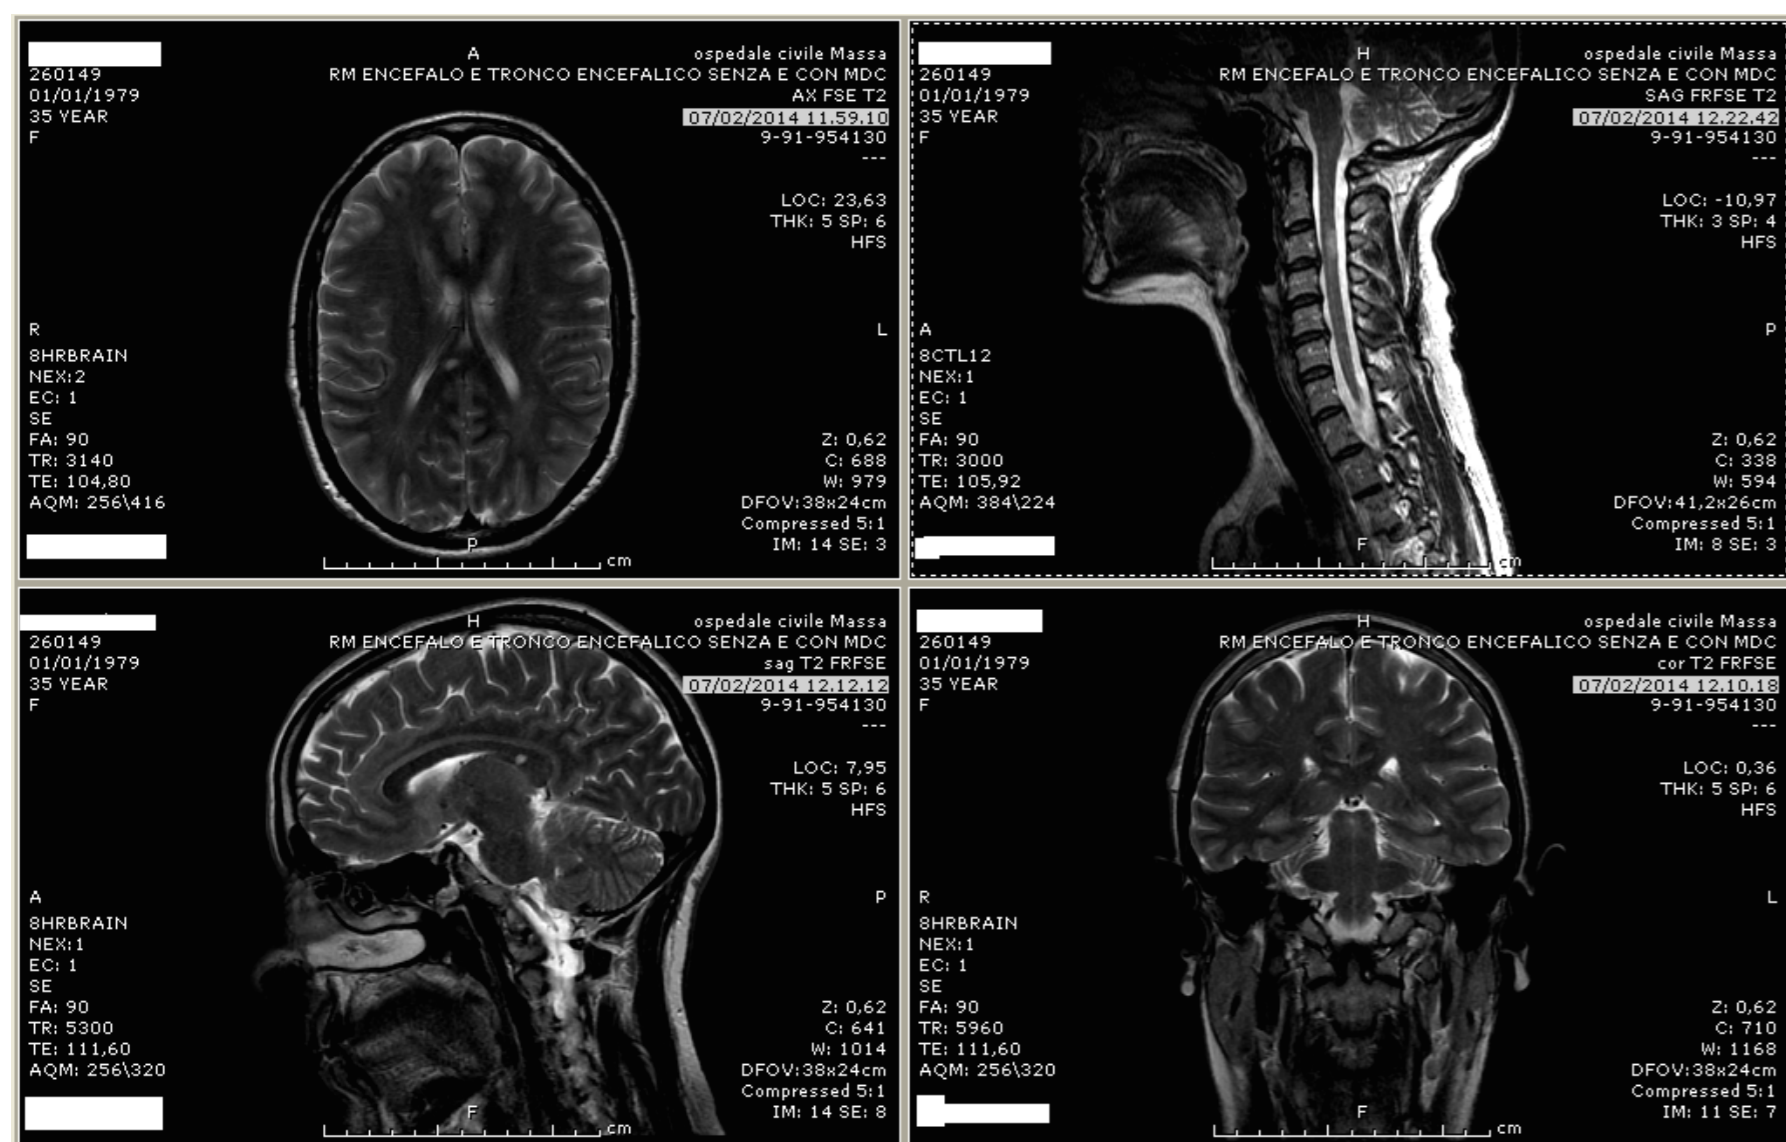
MRI T2 image showed increased signal intensity near the corpus callosum and in the c-spine.
